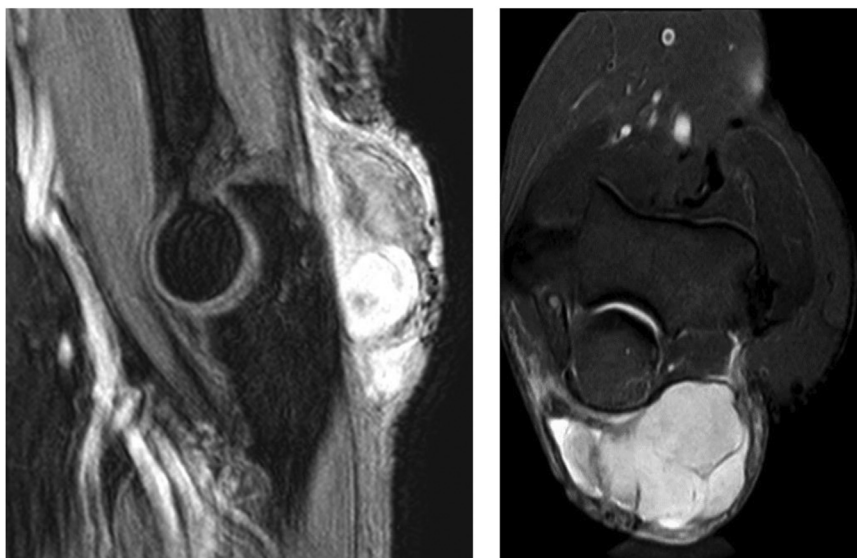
Magnetic resonance imaging (MRI) images with enhancement taken before surgery (left) sagittal short tau inversion recovery sequence, (right) axial transverse relaxation time MRI, postcontrast, showing heterogenous soft tissue mass with perilesional edema and extension into the triceps tendon with enhancement.
